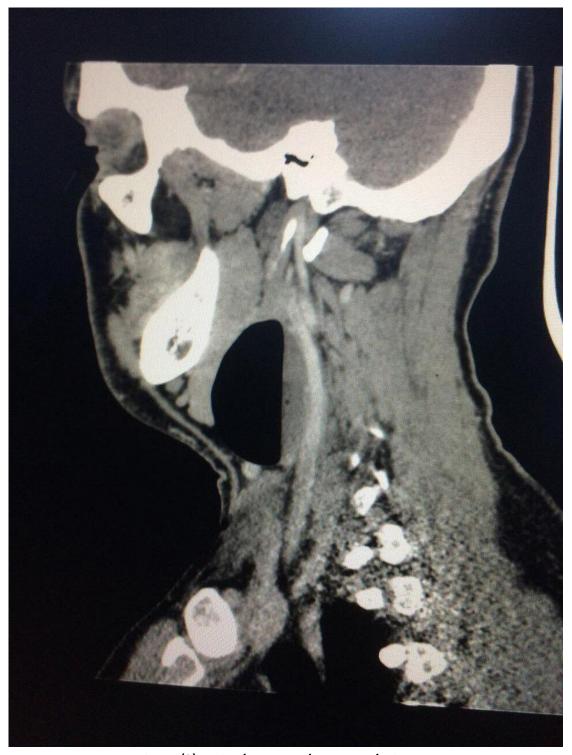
sagittal computed tomography image.
